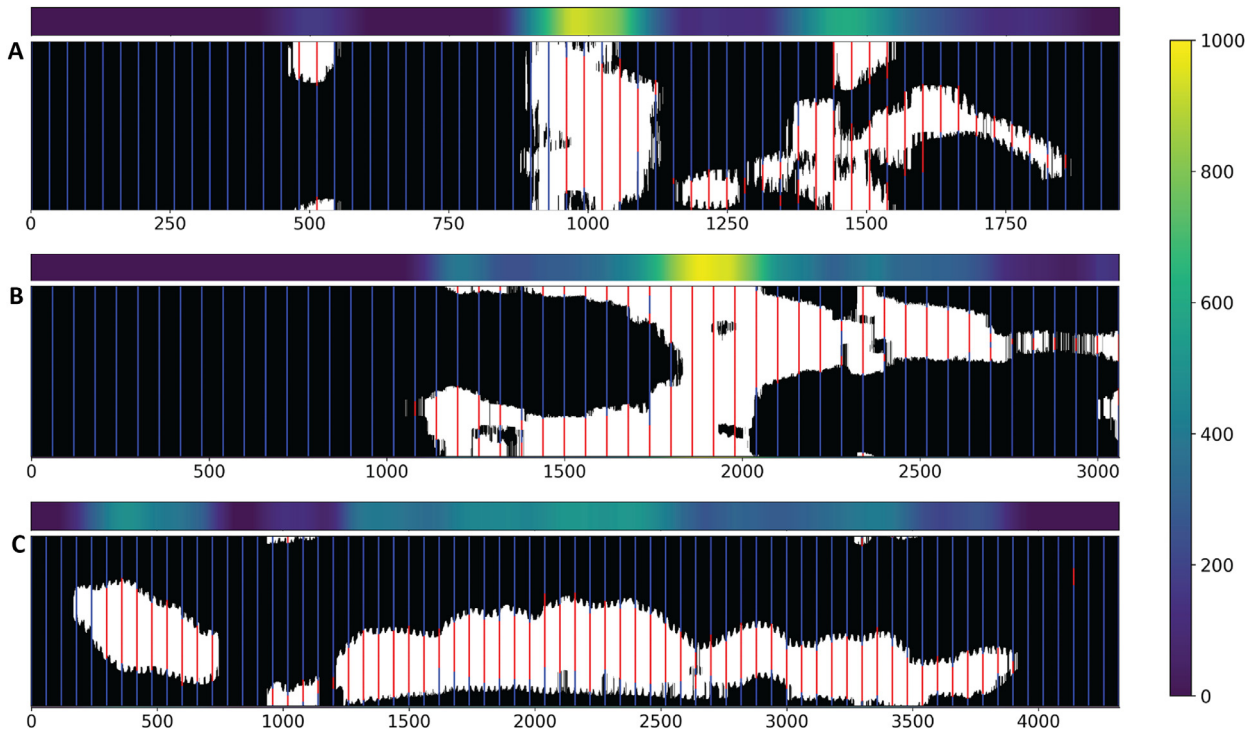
Detection results in carpet views (circumferential angle \times frame number), where detected calcified regions are in *white* and non-calcified regions are in *black*. Positive manual labels are represented by *red lines*, and the negative counterparts, by *blue lines*. The colored strip above each carpet view represents the local intravascular ultrasound calcium score (2 mm windows), ranging from 0 to 1000 (colorbar on the right). Examples from three different systems: (a) Infraredx, (b) Volcano, (c) Boston Scientific.
